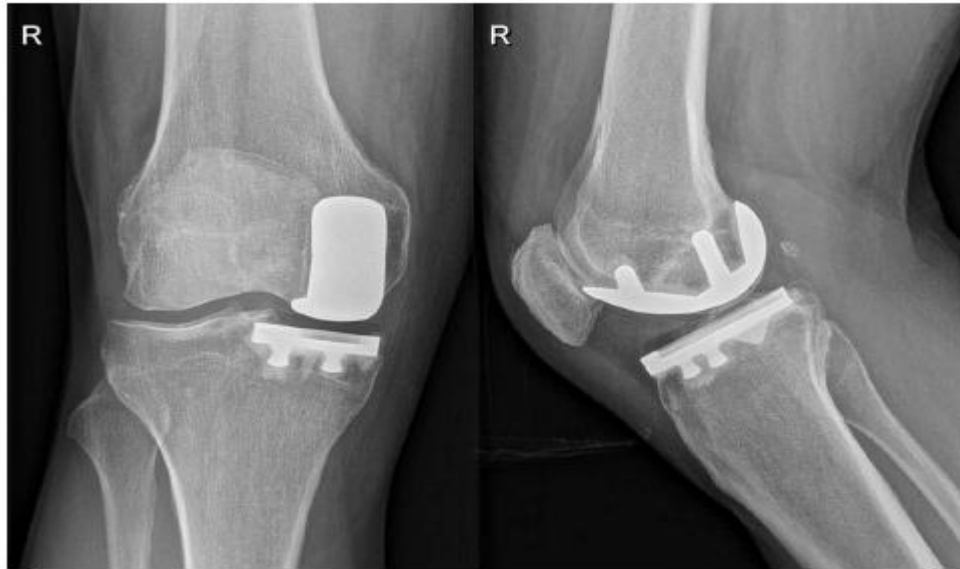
X-ray (AP & Lat.) knee shows a well-fixed and stable UKA implant.^[15]
